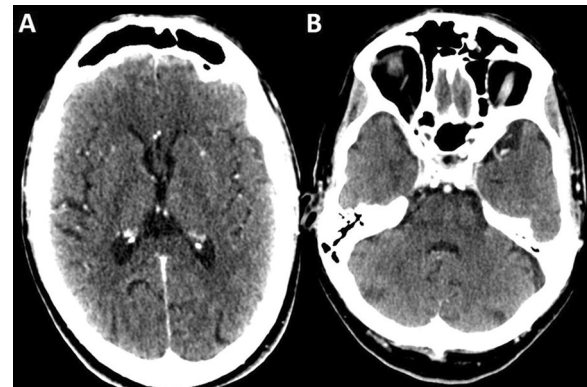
Contrast-enhanced head computed tomography scan. A Supra-tentorial region shows a few millimeter diameter areas of enhancement at the putamen level. B Sub-tentorial region shows no clear areas of enhancement in the cerebellum
